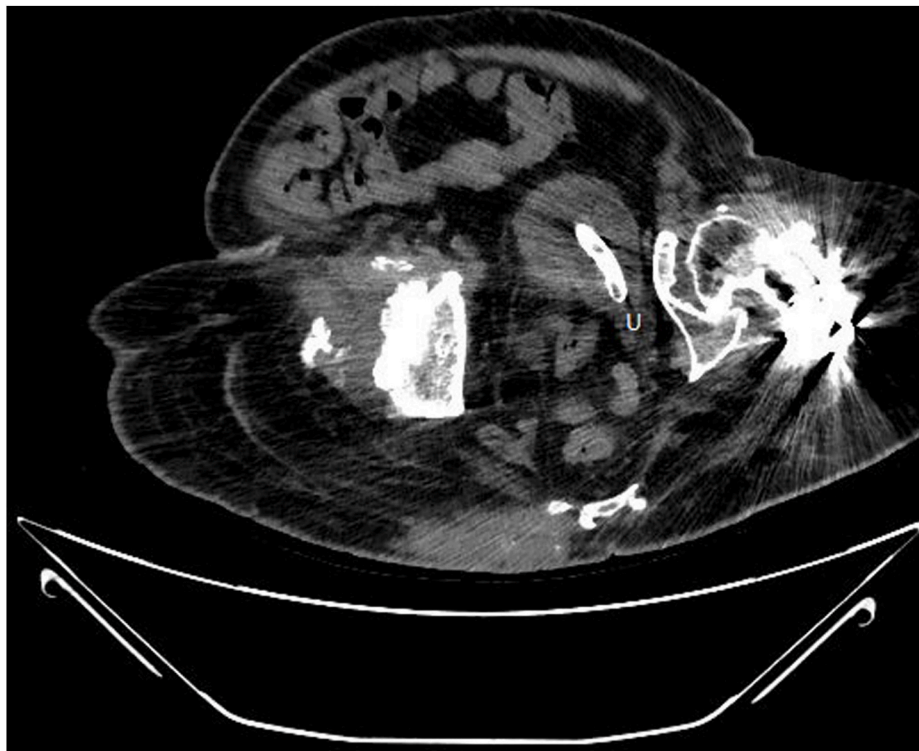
Computed tomography shows suprapubic catheter tip inside the distal ureter. U –ureter.
